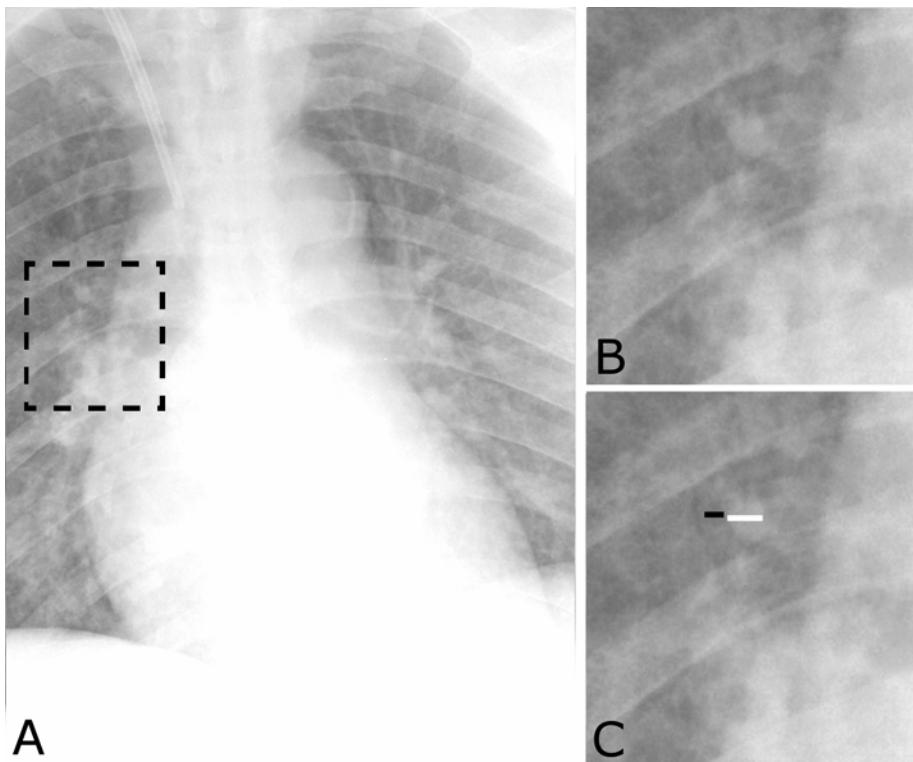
Pulmonary vascular engorgement. A. Frontal radiograph shows widening of the vascular pedicle (indicating a large circulating vascular volume) but close evaluation of the region within the rectangle (exploded into views B, unmarked, and C, marked), shows a pulmonary artery (white line measures diameter) that is much larger than its adjacent bronchus (black line measures diameter).
